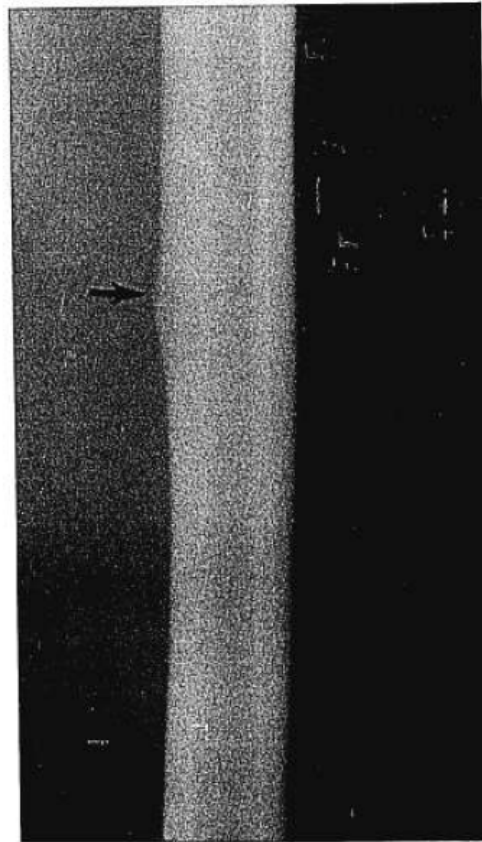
(Patient 21) Anteroposterior roentgenogram of midshaft of left femur shows localized area of periosteal new bone formation (stress fracture) on medial side (arrow).
